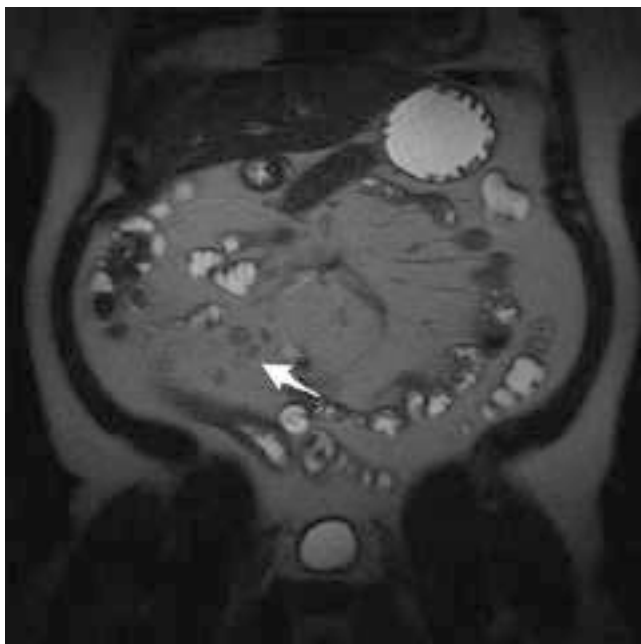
MRE in Crohn's disease. Coronal T2-weighted images with surrounding fibrofatty proliferation and ileocolic lymph nodes (*white arrow*).
